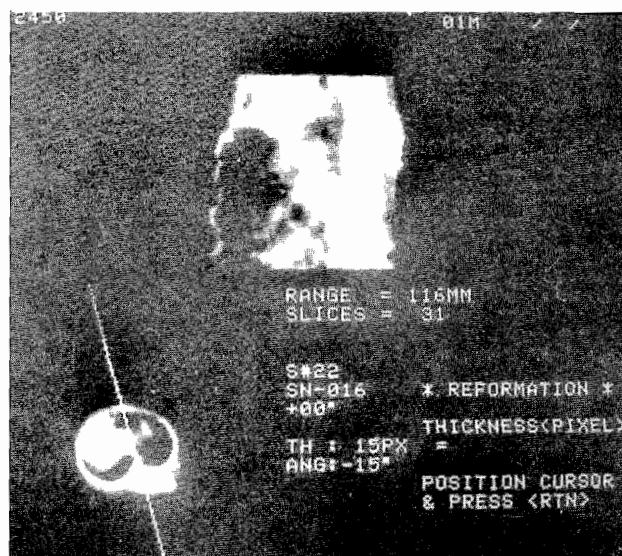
CT myelogram showing contrast filled spinal mass
